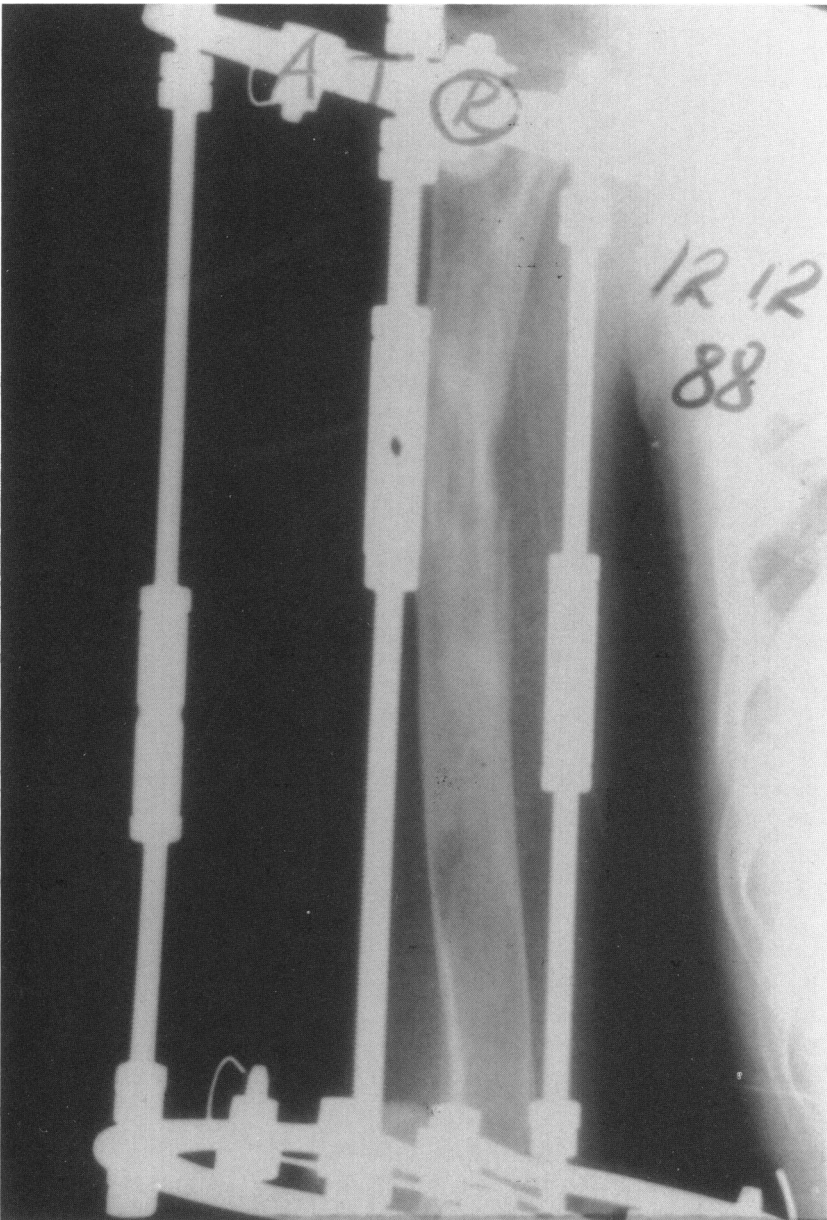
X-ray of the right lengthened segment (11 cm) in the apparatus. Reproduced by permission from Atar, D., et al.: Ilizarov technique in treatment of congenital hand anomalies. *Clin. Orth. Rel. Res.* 273: 268-74, 1991.
